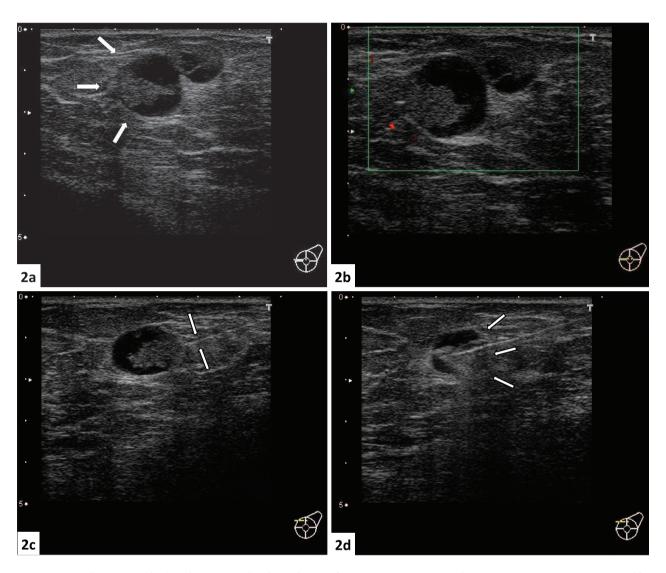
Breast ultrasonography (a) Ultrasonography showed cysts of $15.5 \times 21.0 \times 15.6$ mm and $11.2 \times 11.7 \times 10.1$ mm, accompanied by posterior echo enhancement and a papillary tumor of $15 \times 10 \times 10$ mm, which protruded into the inner cavity. The tumors were accompanied by a lateral shadow and enhancement of posterior echo. (b) Color Doppler of ultrasonography showed a surrounding vascular pattern. (c) The CNB needle was seen as a linear diagonal shadow from the right side to the anterior side of the tumor. (d) The CNB needle was securely inserted into the solid tumor without touching the cyst.
